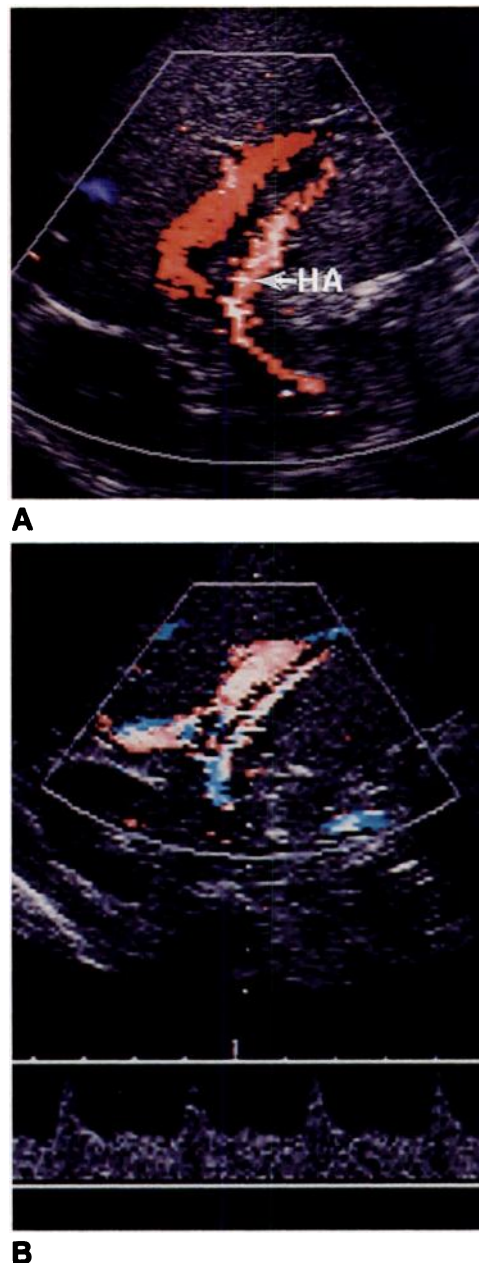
A and B, Transverse color Doppler images alone (A) and in conjunction with duplex analysis (B) in patient with transplanted left-lobe hepatic allograft show hepatic artery (HA) running parallel to portal vein in porta hepatis.
